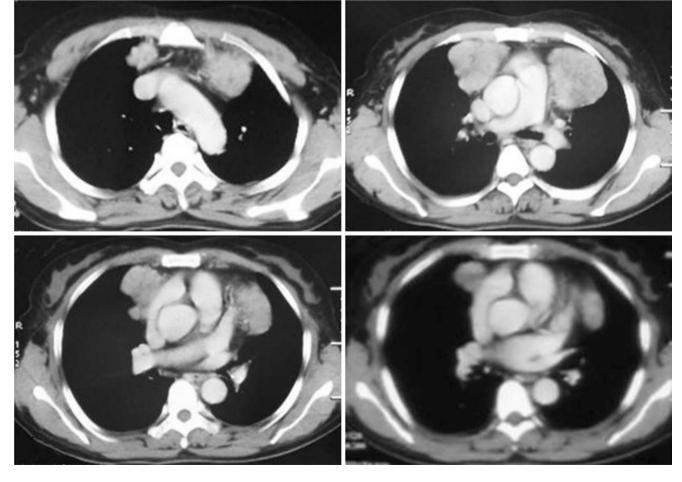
Chest CT images of a 59-year-old woman complained of palpitation and fatigue for 1 month
